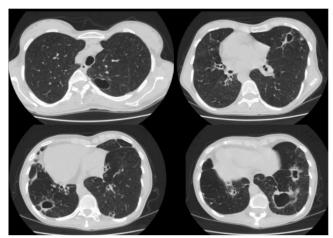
Regression in the cavitary lesions revealed on thorax CT at 8# month follow-up
